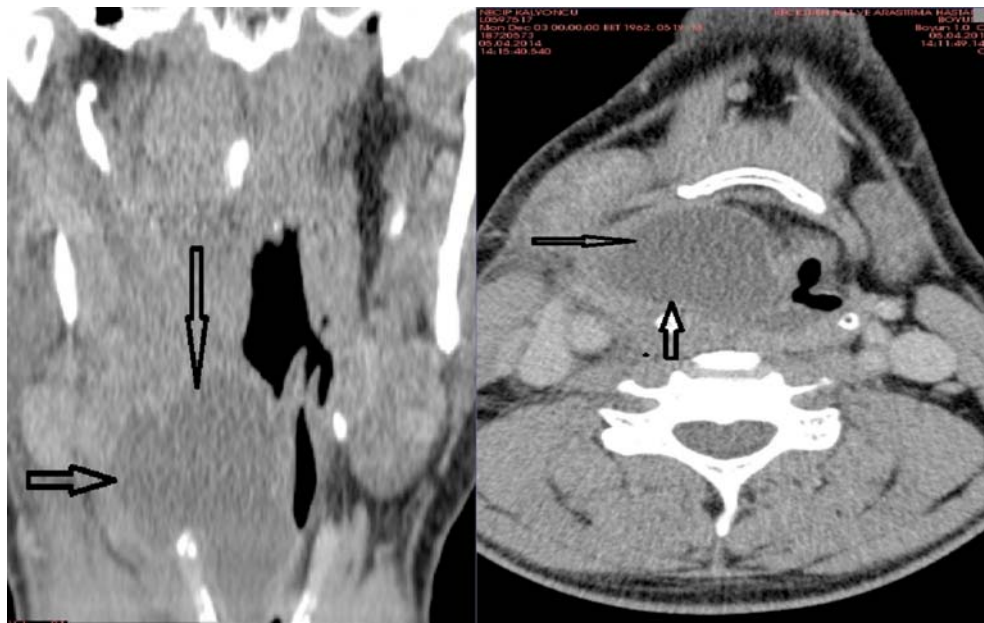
A (CT) scan revealed a mixed large sac.
